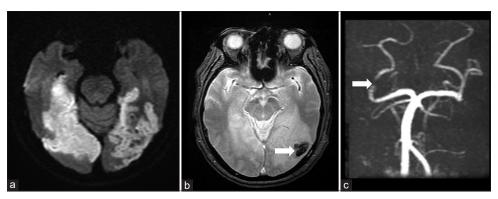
Brain MRI showed (a) high signal over bilateral occipital lobe involving visual cortex and right thalamus (not present here) in diffusion-weighted image. (b) Hemorrhagic transformation was found in GRE sequence. (c) MRA showed diminished flow over right PCA P2 segment
